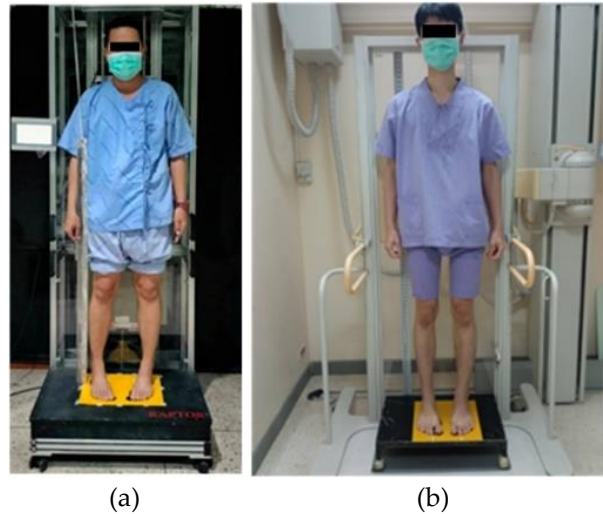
Patient's position for LLSR capturing using (a) RAPTOR and (b) standard X-ray generator. LLSR, long leg standing radiography; RAPTOR, Rapid Orthoroentgenography Making Machine.
